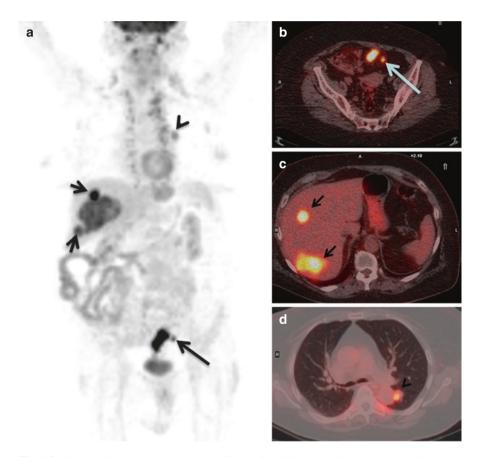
Staging of colorectal cancer on FDG PET-CT. 86-year-old female with rectal bleeding due to a primary sigmoid cancer confirmed on colonoscopy. FDG PET-CT MIP image (a) demonstrating high intensity FDG uptake in the sigmoid lesion and in a small adjacent pericolonic node (long arrow). Staging MR had shown several adjacent pericolonic nodes however these are below PET-CT resolution and were partly obscured by the bloom associated with the intense uptake in the primary. Axial fused images of the same patient showing the intense uptake in the sigmoid tumour and adjacent node (long arrow in b), multiple FDG avid hepatic metastases are also clearly seen (short arrows in c) and a FDG avid pulmonary metastasis is also noted (arrow head in d). PET-CT has the unique ability of providing complete staging information as a single hybrid modality
